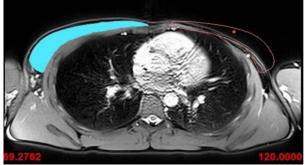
MRI slice with highlight of contralateral pectoralis muscle (blue) and mirror outlining
